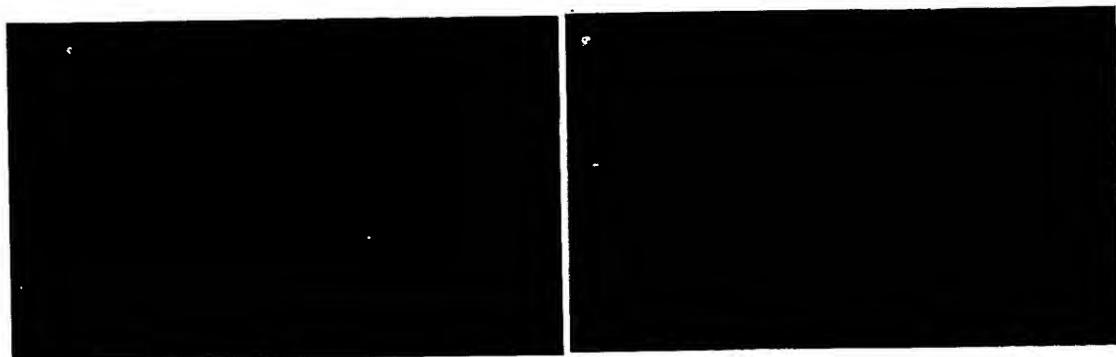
Pictures of embolic flow in the bifurcating vessels in the absence of power ultrasound (control experiment, left picture) and with power ultrasound ON (right picture)
